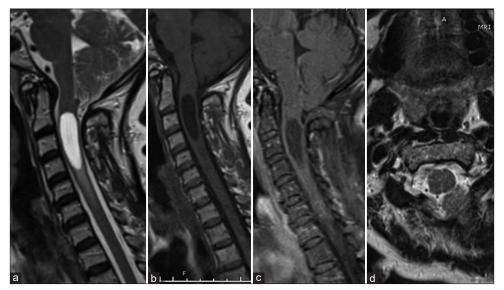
Preoperative magnetic resonance imaging (a) sagittal T2-weighted, (b) T1-weighted, (c) T1 post-contrast, and (d) axial T1 post-contrast views. There is a Chiari I malformation, with inferior descent of the cerebellar tonsils below the level of the foramen magnum by approximately 8 mm.
